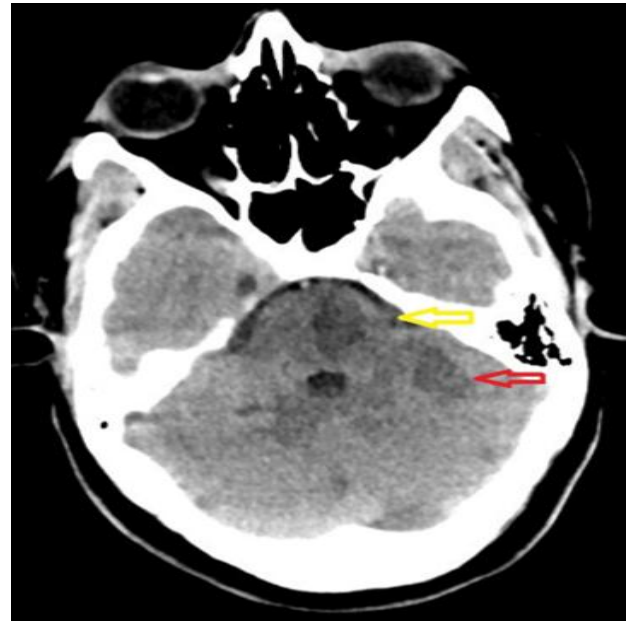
Non-contrast CT scan of the brain demonstrates a hypodense area in the left cerebellar hemisphere (yellow arrow), and in the left pons (red arrow) consistent with acute infarct.
